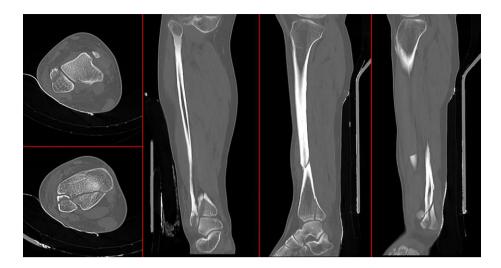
Axial and lateral CT showing the oblique spiral fracture in the tibial shaft, lateral malleolar fracture, posterior malleolar fracture and anteroinferior tibiofibular (AITF) ligament avulsion of patients.
